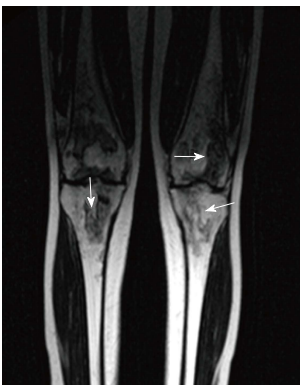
Magnetic resonance imaging (bilateral knees, T1-weighted images, coronal view) showing areas and serpiginous rims of low signal intensity in the femurs, tibiae and patellas, characteristic of osteonecrosis.
